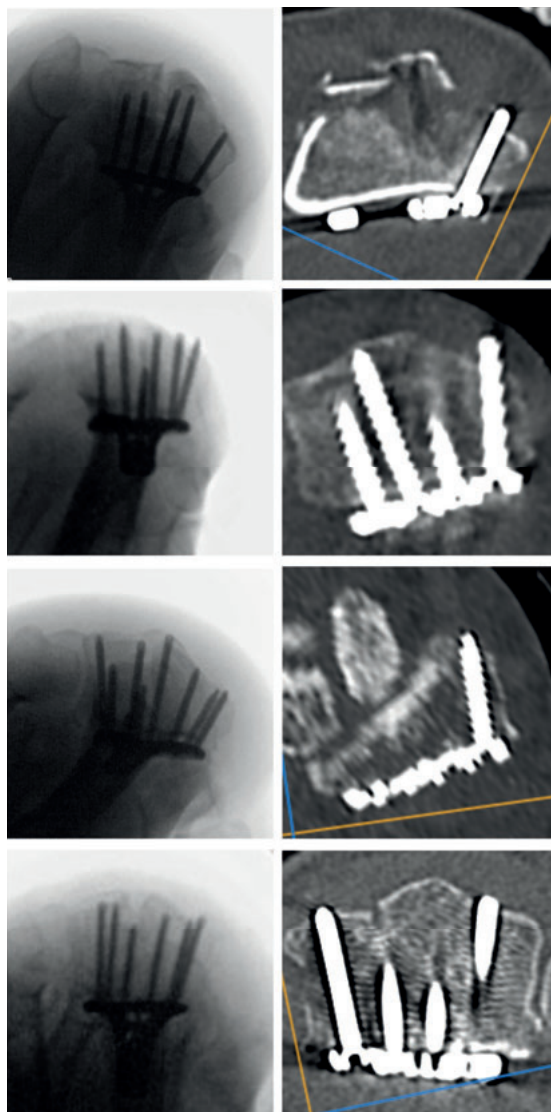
Out of the 16 patients that had intra-operative screw revision after obtaining DTV, in four of these patients (25%), a total of four other screws were still found to be protruding on postoperative multiplanar CT reconstructions. On the left side the final DTV (after screw revision) with on the right sight the matching post-operative multiplanar CT reconstructions.
